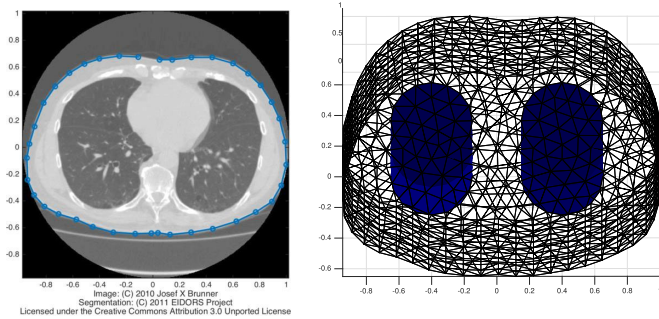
Human adult male thorax CT outline (left) and extruded mesh used for reconstruction aggregation (right).
